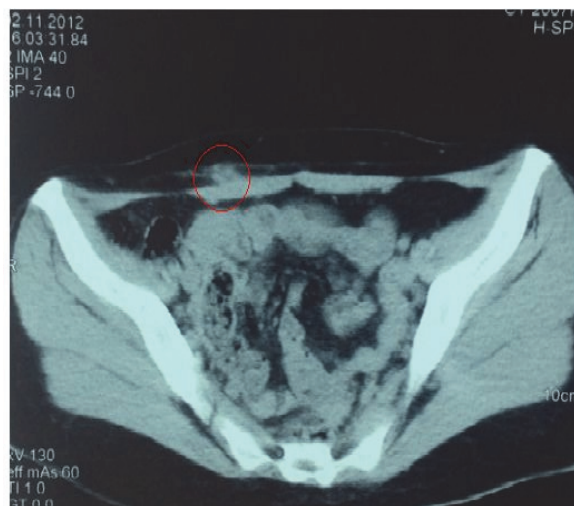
The CT image of the solid and heterogeneous mass along the subcutaneous tissue on the right rectus abdominis muscle.
